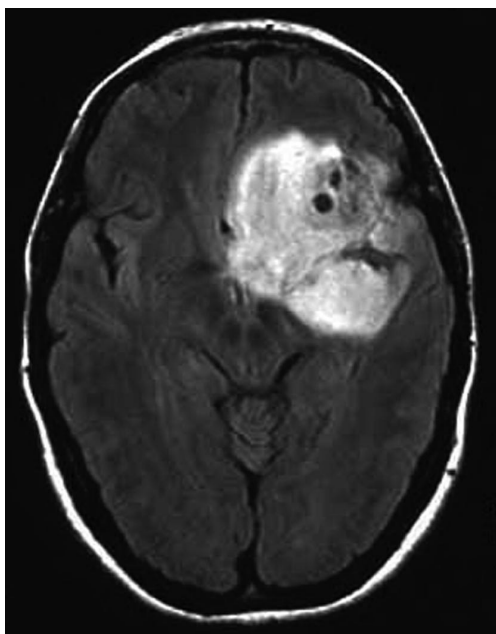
Magnetic resonance image (FLAIR sequence) of an unenhancing low density lesion on T1-weighted images (not shown) suggestive of a low grade glioma (grade 2 astrocytoma or oligodendroglioma).
